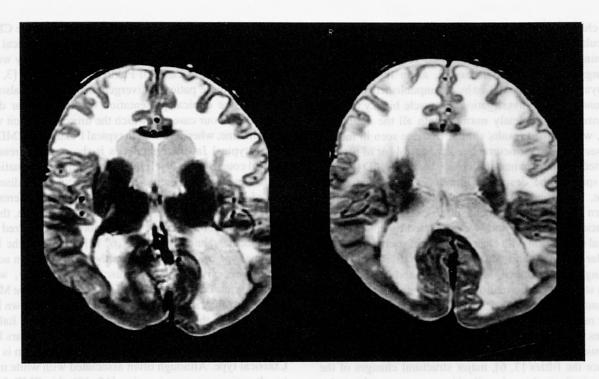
Brain MRI of case 1. In these two axial T2 images (TR 2000; TE 90) there is clear evidence of pachygyria in the occipital lobes, widely enlarged ventricles and severe white matter abnormalities, mainly in the anterior regions.
